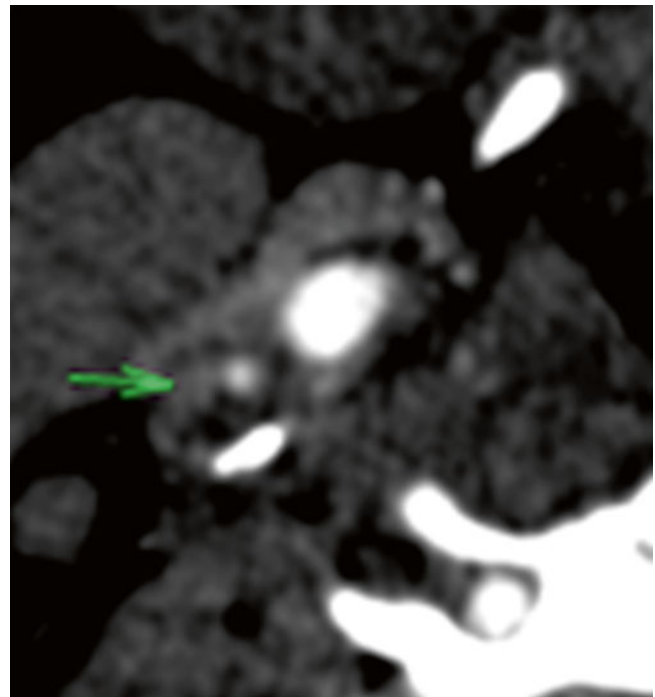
That enhancement of the vasa vasorum (indicated by arrow in image) adjacent to severe carotid plaque during arterial phase CTA
